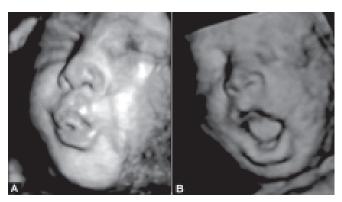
A sequence of images recorded by 4D sonography showing fetal mouth opening movements at 16 weeks of gestation
